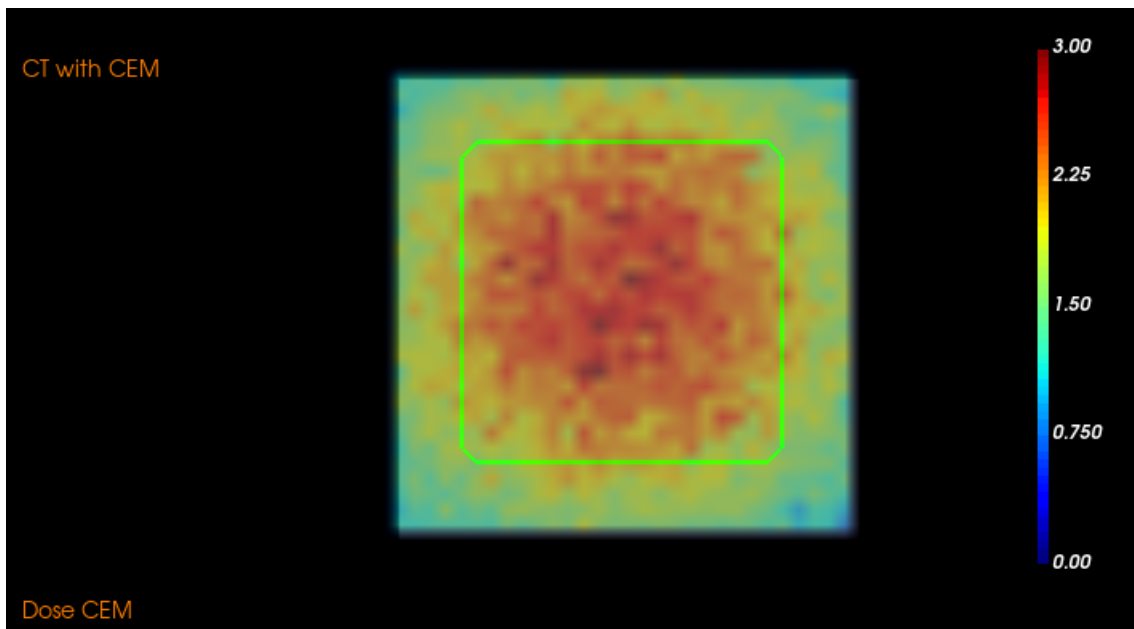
Example of a transversal slice of a CT with the target volume and the dose map
